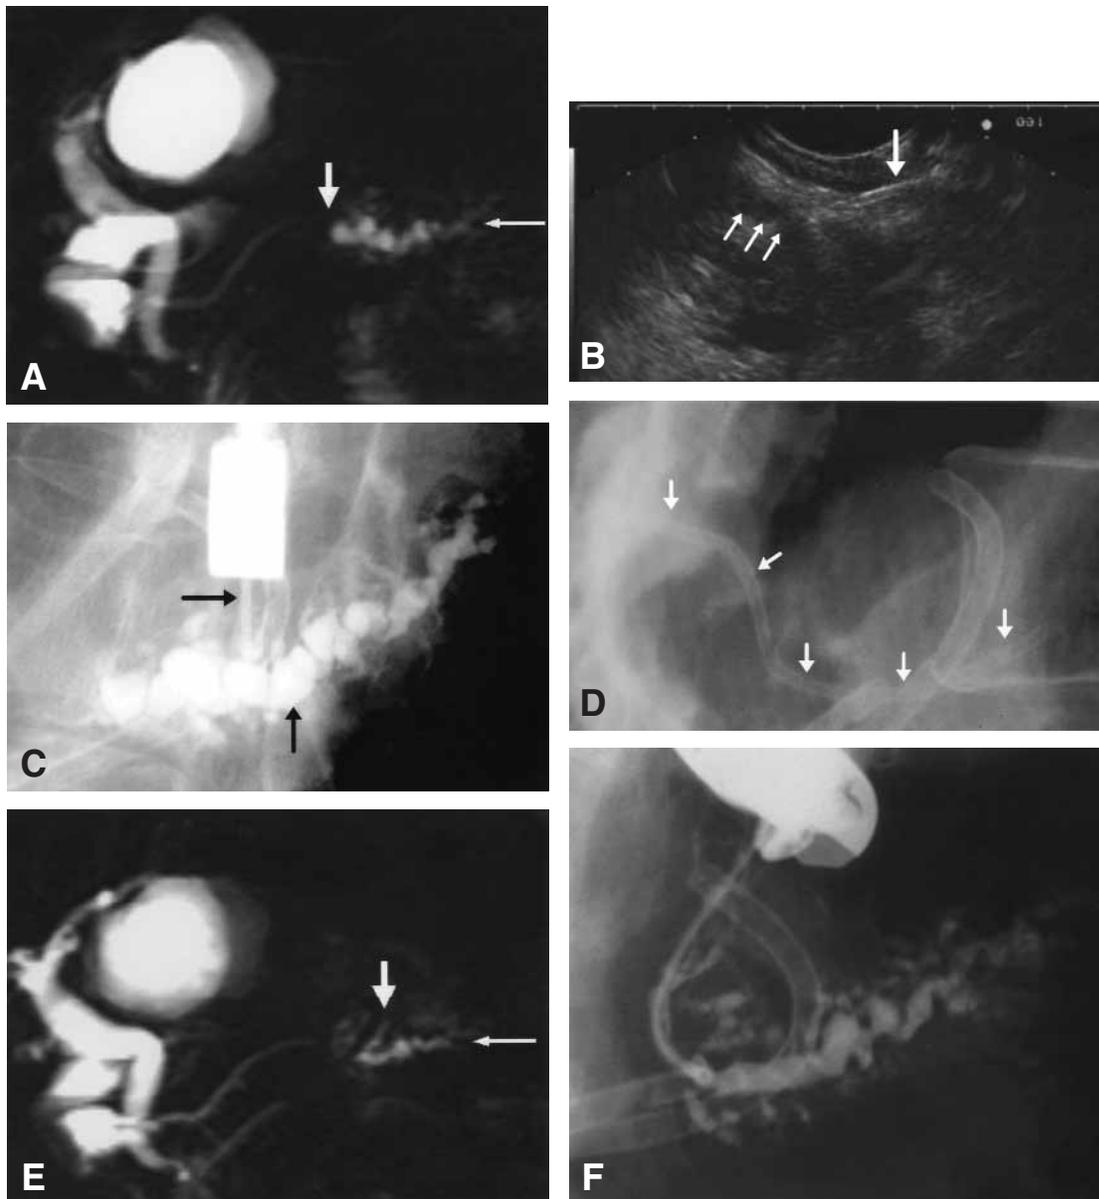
Patient 2. A, Secretin-enhanced MRCP image before EPG. The caudal pancreatic duct (*thin arrow*) is dilated proximal to a complete obstruction (*thick arrow*). B, EUS image of pancreatic duct (*small arrows*) and needle entering duct (*large arrow*). C, Radiograph showing opacification of dilated proximal pancreatic duct (*vertical arrow*) after EUS-guided puncture with needle catheter (*horizontal arrow*). D, Radiograph showing pancreaticogastric stent in place (*arrows*). Stents placed during previous cystenterostomies are also apparent. E, Secretin-enhanced MRCP after EPG. The caudal pancreatic duct (*thin arrow*) has decreased in diameter, and drainage through the pancreaticogastric fistula leading to the stomach is visible (*thick arrow*). F, Radiograph obtained 13 months after EPG. After removal of the stent, the fistula has been recannulated with a balltip catheter and the dilated duct has been opacified.
